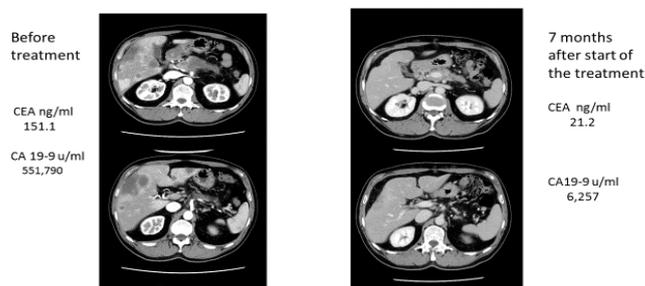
CT findings and the level of tumour marker before treatment and 7 months after the start of the treatment.
